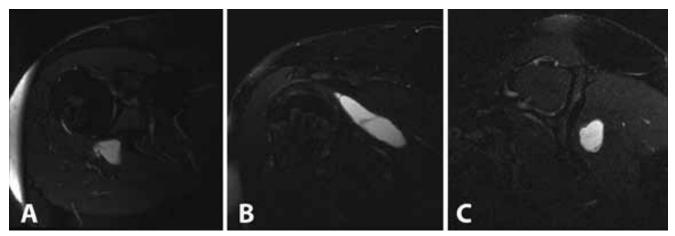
Axial T<sub>2</sub>-weighted (A), coronal T<sub>2</sub>-weighted (B), and sagittal T<sub>2</sub>-weighted (C) magnetic resonance imaging shows large intramuscular infraspinatus cyst with hyperintense, single-loculation, round, homogeneous-appearing cystic mass.
